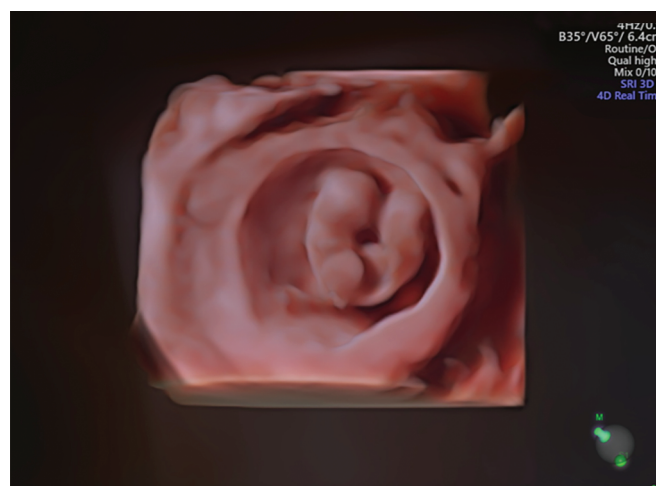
Three-dimensional ultrasound image accurately delineates the level of fusion to be at lower abdomen and pelvis
